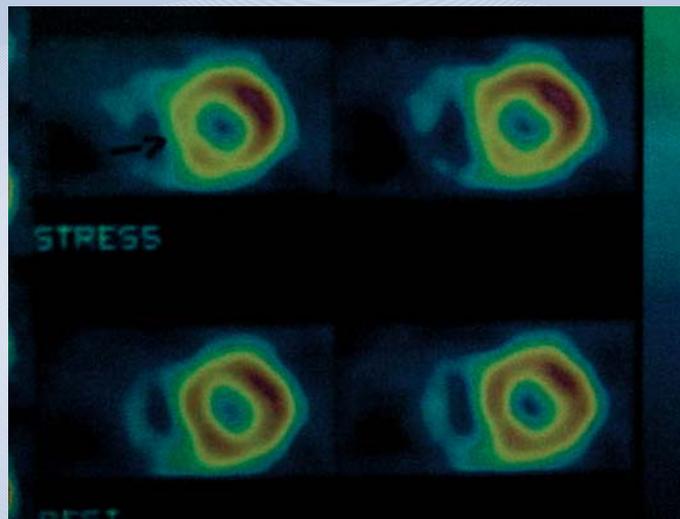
Stress (top row) and rest (bottom row) myocardial scintigraphy (Tc-99 sestamibi) showing anteroseptal ischemia
